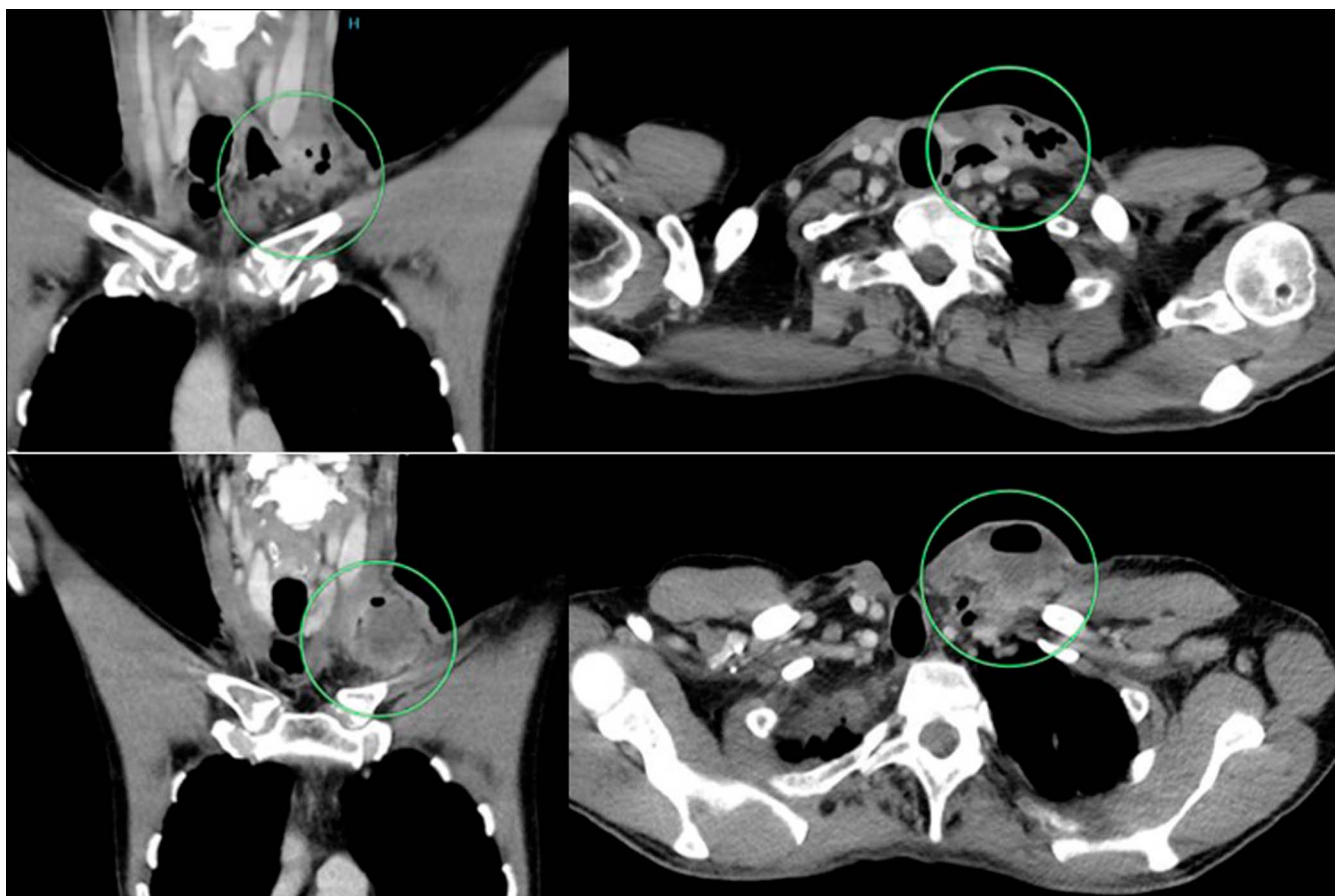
CT-scan results, the upper row is at first presentation, the second row after 1 week of antibiotic treatment, with abscess progression.
